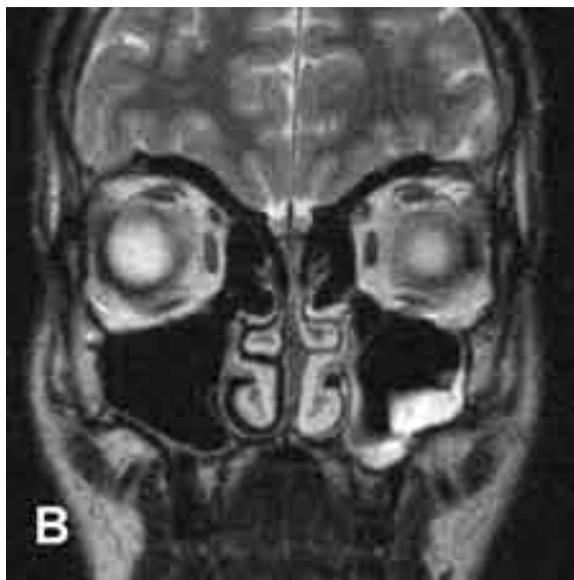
Patient S.R. CT (a) and MRI T2-weighted (b) in the frontal plane 2 days after surgical intervention and application of the polypropylene fabric on the orbital floor. Bone frame of the left orbit is surgically reconstructed. Alloplastic material is not visible. c: CT and MRI fusion. Red line indicates place of the fabric implantation on the left orbital floor.
